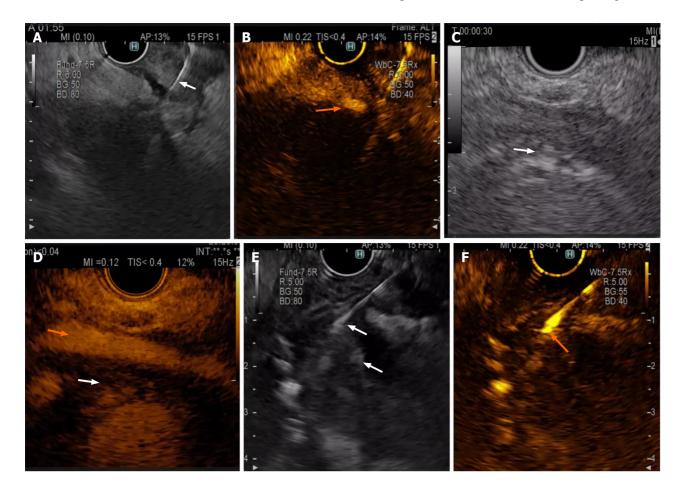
Contrast-enhanced endoscopic ultrasound. A and B: Contrast-enhanced endoscopic ultrasound (CE-EUS)-guided fine needle aspiration (FNA). CE-EUS-guided FNA (white arrow) of a pancreatic mass suggestive of adenocarcinoma. A large vessel near the gut wall is more visible during contrast enhancement (orange arrow); C and D: CE-EUS view of perivascular tumour infiltration. CE-EUS view of perivascular tumour infiltration (superior mesenteric artery, orange arrow) as a hypoenhanced rim (white arrow, both images) around the artery in a patient with pancreatic head adenocarcinoma; E and F: Contrast enhanced endoscopic ultrasound-guided FNA from a hyperenhanced mural nodule inside a branch-duct intraductal papillary mucinous neoplasm (IPMN). CHEUSFNA was performed on a hyperenhanced mural nodule inside a branch-duct intraductal papillary mucinous neoplasm (IPMN). CHEUSFNA was performed on a hyperenhanced mural nodule inside a branch-duct intraductal papillary mucinous neoplasm (IPMN). Second and the arrows) is shown. On the right, only one of the nodules was hyperenhanced by the contrast agent, so endoscopic ultrasound-guided FNA sampling was performed.
